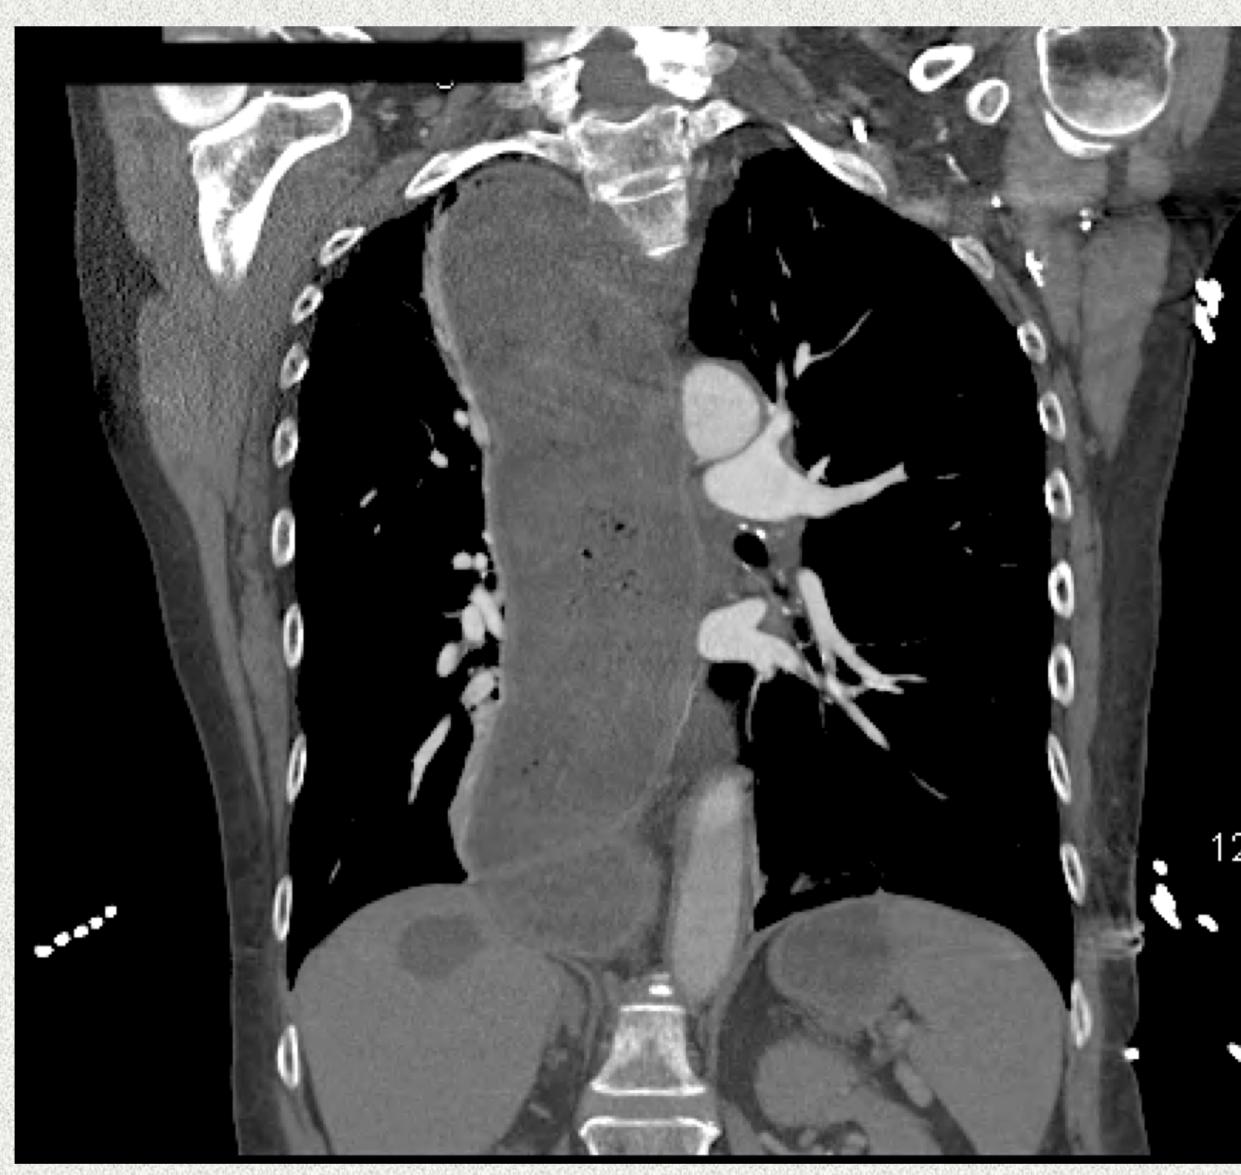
CT angiogram of chest and abdomen (coronal view) showing megaesophagus measuring 6 cm in diameter containing a large amount of debris.
